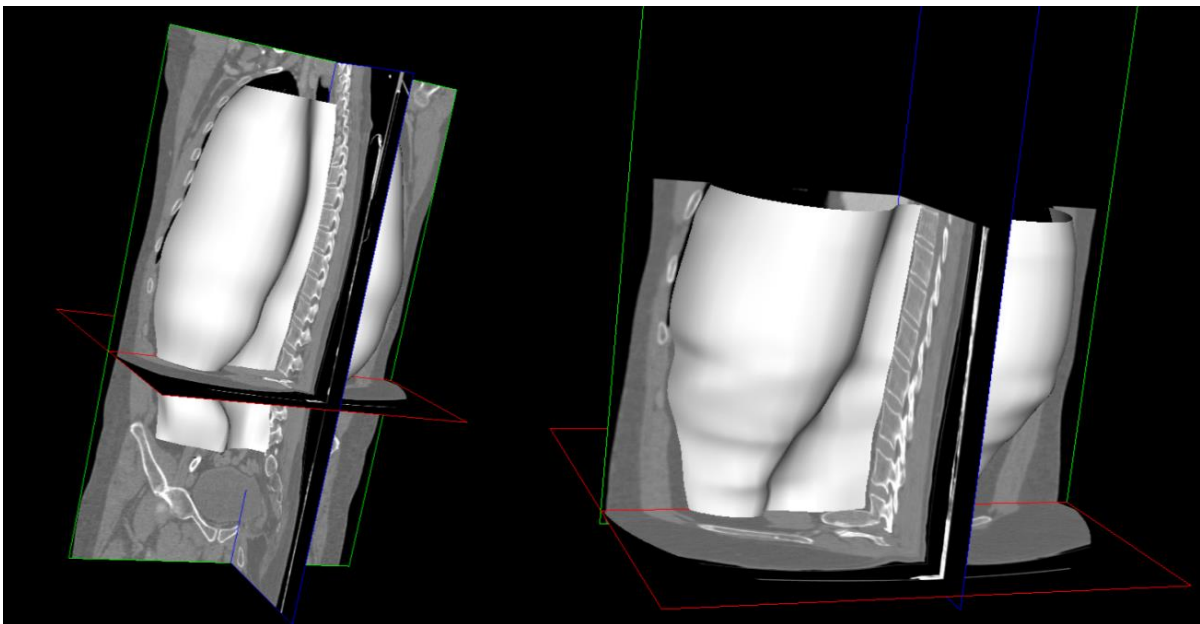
The generated meshes from the venous (left) and arterial (right) phases CT image.
